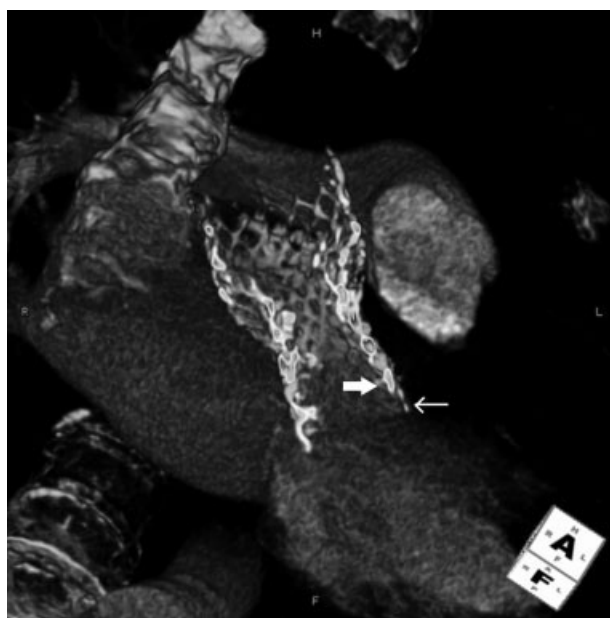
CTA (sagittal view) demonstrating CoreValve-in-Core-Valve prostheses.
